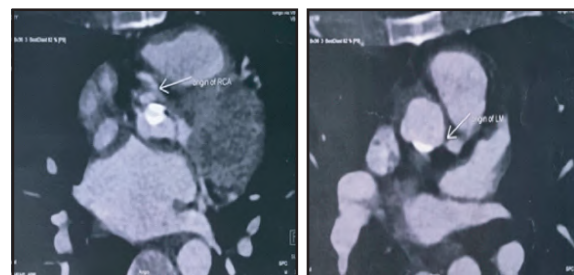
(a,b) CT angiogram showing severe left main stenosis
